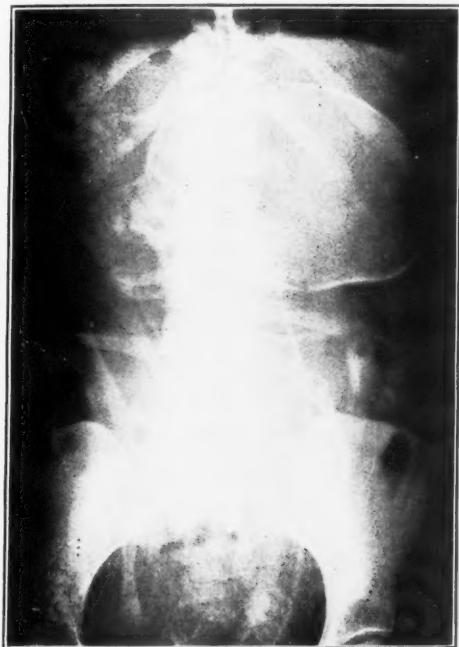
Anteroposterior roentgenogram from Case 1, from which the diagnosis of hydrocephalus was erroneously made. Note the absence of characteristics of hydrocephalus and the tendency toward occipital flattening. Tube-film distance of 30 inches employed.
